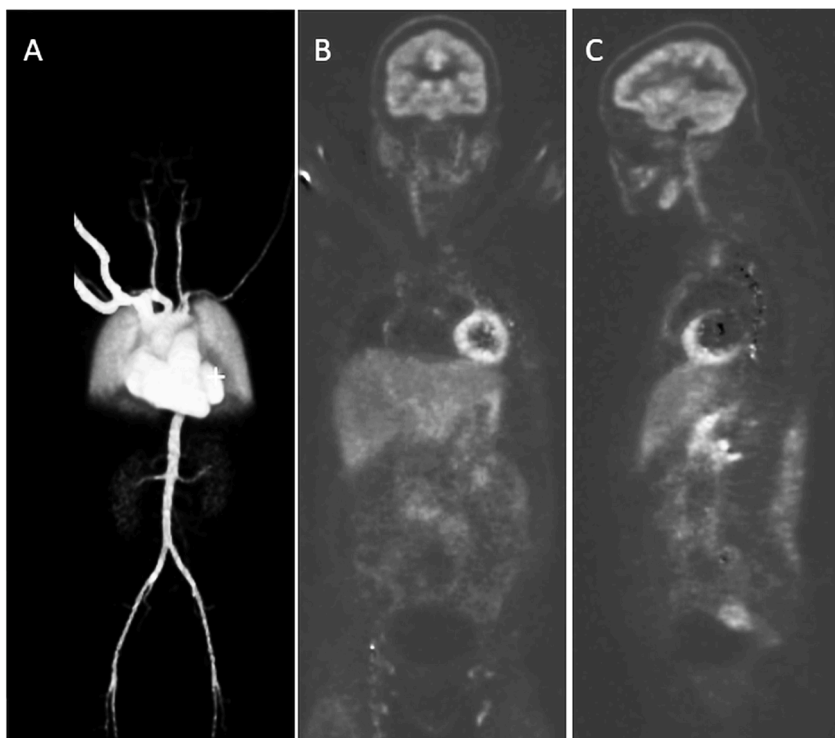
Whole-body dynamic perfusion PET imaging using ^{15}O -water. Dynamic perfusion imaging with ^{15}O -water acquired using the Biograph Vision Quadra large axial field of view PET/CT system (Siemens Healthineers). (A) Three-dimensional parametric image of arterial blood volume (V_a). (B and C) Parametric images of organ-specific blood flow (k_1 , mL/min/mL) in horizontal (B) and sagittal (C) planes, respectively. High perfusion is visible in the myocardium and kidneys in images centered on the heart. PET/CT, positron emission tomography/computed tomography.
